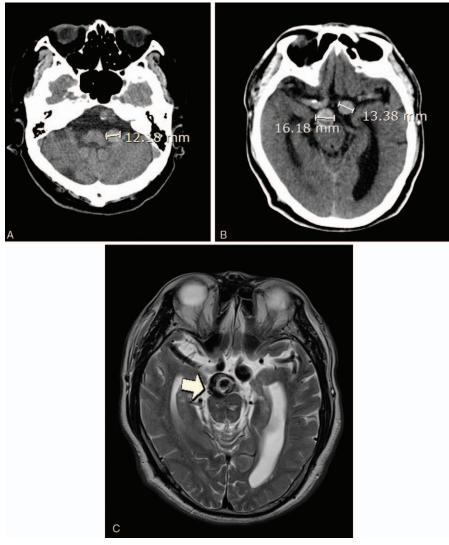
Nonenhanced CT revealed wide vertebrobasilar artery and fusiform aneurysmal dilation of the left supraclinoid portion of the ICA: vertebral artery -12 mm, basilar artery -16 mm, and midsection of left supraclinoid fusiform aneurysm -13 mm (A, B). Brain MR T2-weighted imaging (C) revealed dilated and thrombosed basilar artery adjacent to the right anterolateral aspect of the diencephalon (arrow). CT = computed tomography, ICA = internal carotid artery.
